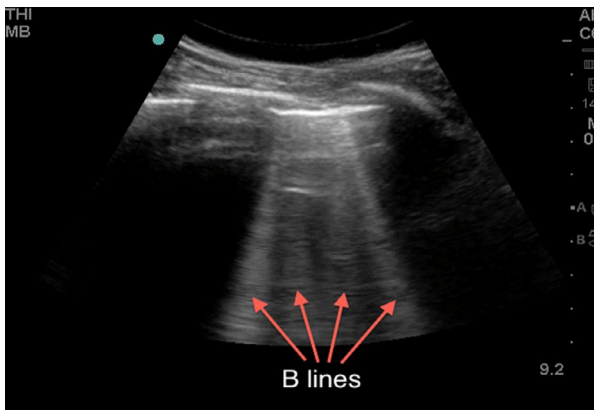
Lung ultrasound image showing vertical artifacts (B-lines) indicating the presence of a pathology associated with increase in lung tissue density. Reprinted with permission from Miller (2016).
